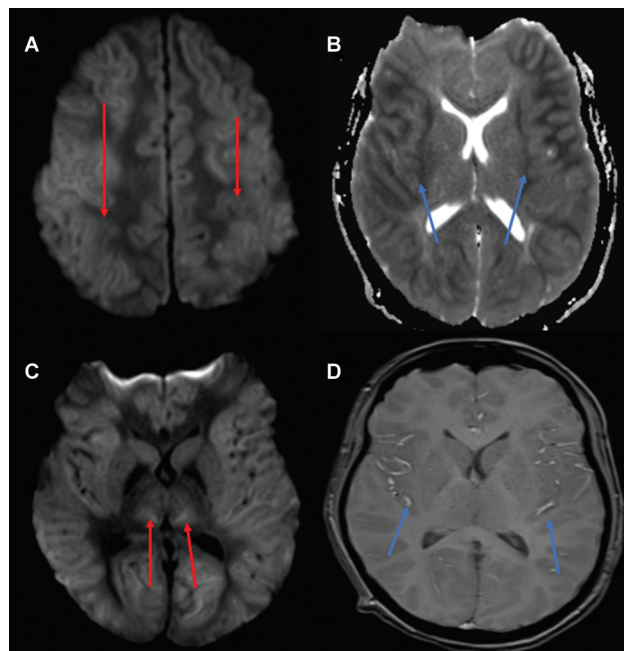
Magnetic resonance imaging (MRI) of the brain. (A) Axial diffusion weighted image shows cortical diffusion restriction with relative sparing of bilateral peri-Rolandic regions (red arrows). (B) Axial apparent diffusion coefficient (ADC) map shows symmetric cortical and juxtacortical cytotoxic edema involving the insular region (blue arrows). (C) Symmetric diffusion restriction noted in bilateral thalami on axial diffusion weighted image (red arrows). (D) Axial susceptibility weighted image (SWI) shows hyperintense signal in cortical veins (blue arrows), suggestive of hyperemic hypoxia in the setting of cytotoxic edema.
